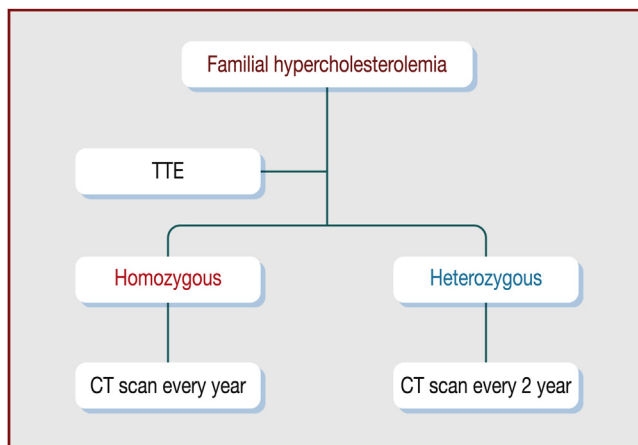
Proposal of transthoracic echocardiography and CT scan follow up for familial hypercholesterolemia subjects. CT: computed tomography; TTE: transthoracic echocardiography.
